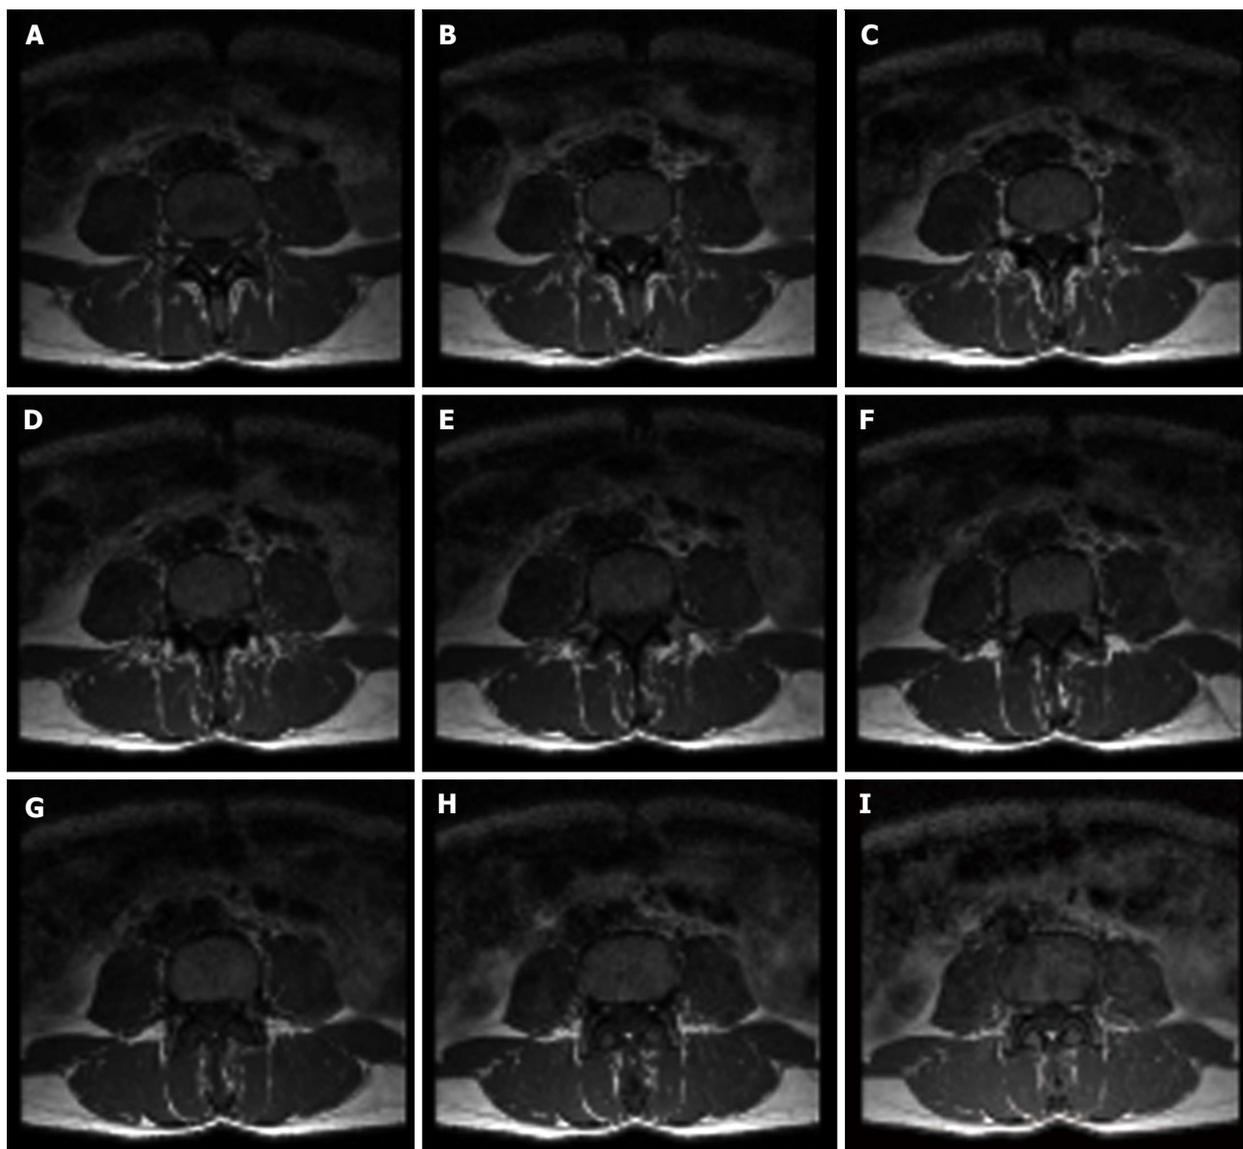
Set of images from magnetic resonance imaging spin-echo. Nine axial images of the fourth lumbar vertebra obtained by magnetic resonance imaging multislice technique. Acquisition of the set of axial images of vertebral body to visualize the inner trabecular bone portion is performed from bottom (A: lower base) to top (I: upper base).
